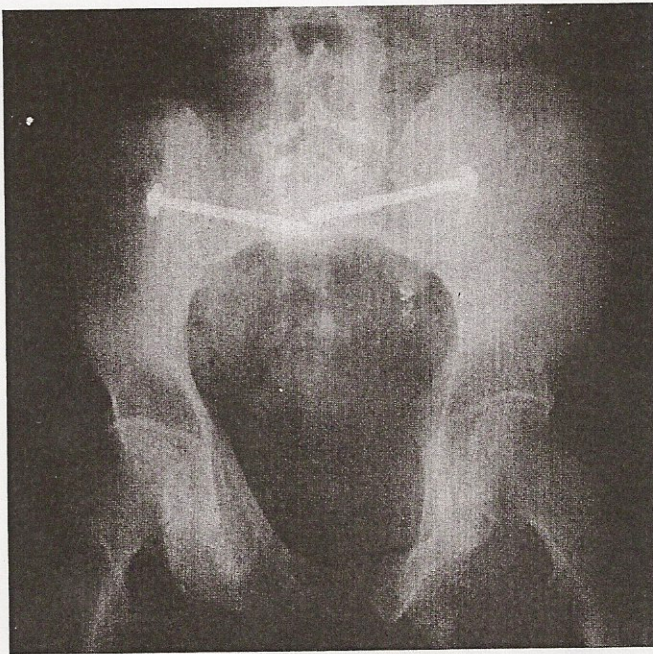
Radiograph at 5 months demonstrating consolidated fractures except for a fibrous union of the right inferior pubic ramus. The patient was full weight bearing and had a nonantalgic gait.
